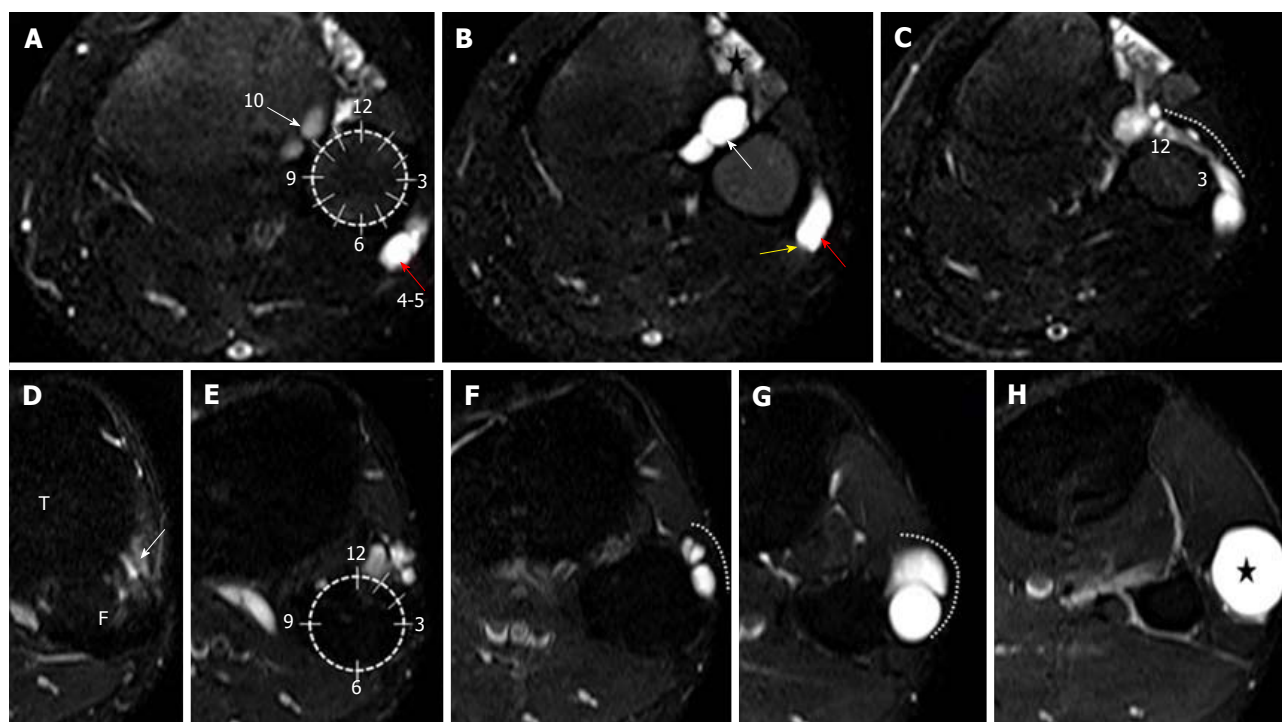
Axial, T2-weighted fat suppressed images A-H of the proximal leg show the left clock face model to differentiate intraneural ganglion cyst from extraneural ganglion cyst. A-C represent INGC where images A, B (at the upper-mid fibular head level) depict the joint connection of the cyst at the 10 o'clock (white arrows) which signifies the "tail sign". The cyst (red arrows) within the outer epineurium of the CPN (yellow arrow), between the 4 and 5 o'clock position represents the "signet ring sign". Image C, (at the level of fibular neck) shows the extension of the cyst along the ascending limb of the articular branch (dotted white line) depicting the "transverse limb sign". It crosses the anterior surface of fibula from the PTF joint and progresses clockwise from 12-3 o'clock position around the fibular head. On the other hand, images D-H, depicting ENGCG show a more superiorly located joint connection (white arrow) in between 12-2 o'clock position in images D, E. It lies anterolateral to the fibula (dotted white line) and never crosses it as seen in images F, G. The cyst (star) is more globular and lying in the intermuscular plane as seen in the image H. INGC: Intraneural ganglion cyst; CPN: Common peroneal nerve; ENGCG: Extraneural ganglion cyst; T: Tibia; F: Fibula.
